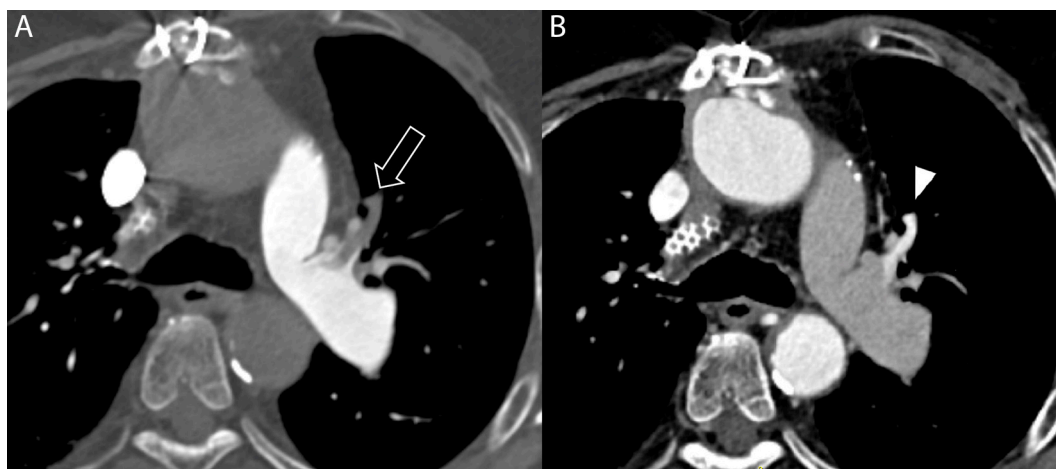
(A) Axial CT image of the chest after administration of contrast during the pulmonary arterial phase demonstrates an unopacified left upper lobe segmental pulmonary artery branch, identified by black arrow. (B) Axial CT image of the chest after administration of contrast during systemic arterial phase imaging (acquired at 28 s delay) demonstrates late opacification of previously unopacified segmental branch, identified by white arrowhead, compatible with MAPCA-to-pulmonary artery connection. MAPCA, major aortopulmonary collateral artery.
